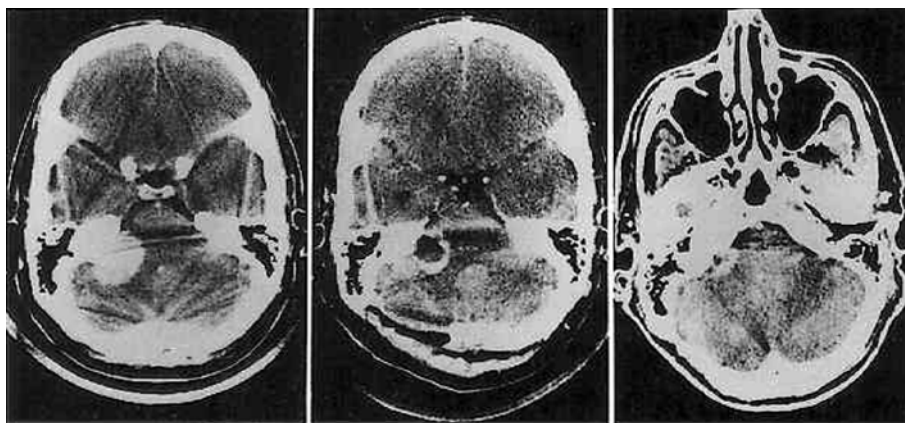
Case 12. Computerized tomography (CT) scans in a 36-year-old man with a large right-sided tumor. *Left:* Preoperative contrast-enhanced CT scan. *Center:* Contrast-enhanced CT scan 6 weeks postoperatively showing that the outer rim of the tumor has partially collapsed. *Right:* On a CT scan obtained 3 years later, only the residual capsule remains.
